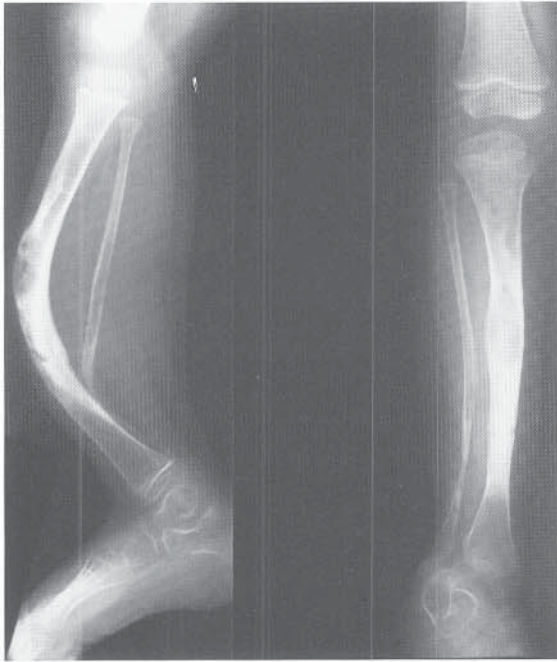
A and B, Newborn radiographs in a girl with neurofibromatosis type 1. The tibias are bowed bilaterally. C, Prophylactic bracing bilaterally was instituted in 1974 at walking age with KAFOs, using thigh laces and free ankle joints. D, At age 2 the right fibula has fractured, but the tibia remains intact. Bracing was continued.
